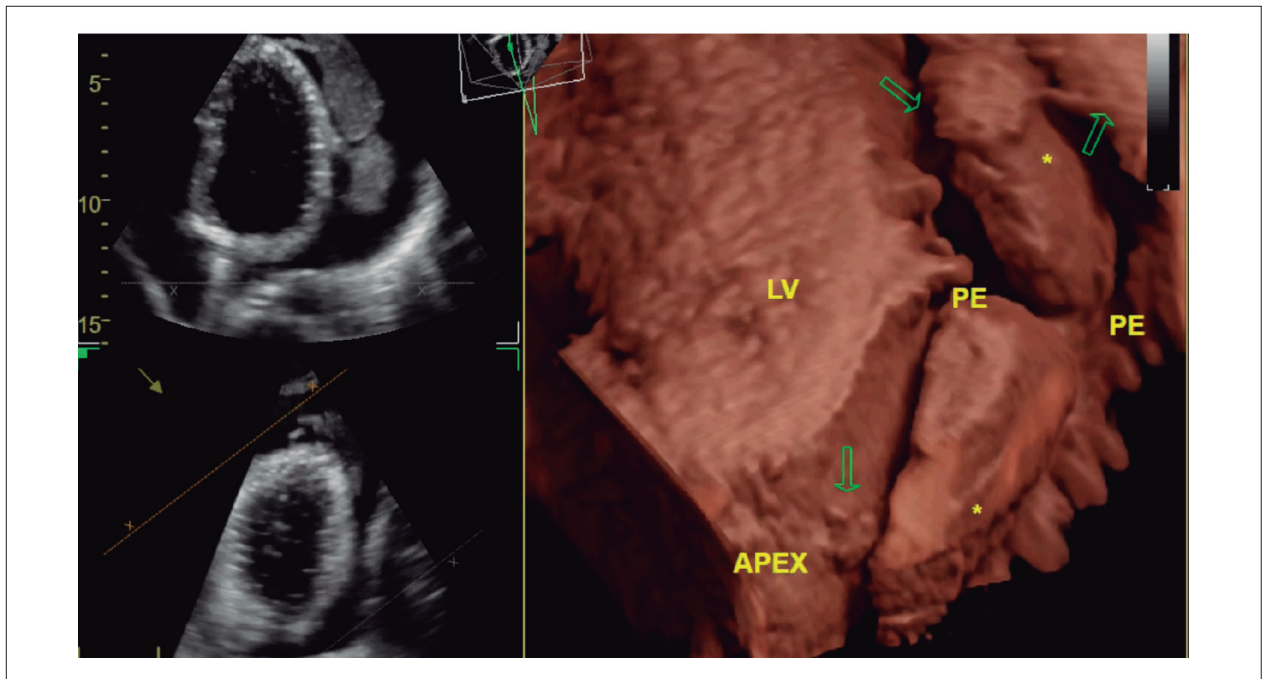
Transthoracic echocardiogram (TTE), showing large pericardial effusion with two intrapericardial masses (*). Two discoid masses were detected by 2D TTE, measuring 5.5 x 2.0cm and 4.3 x 2.3cm in its major diameters, from apical (A) and parasternal views (B). Rendered 3D images were obtained by post processing of datasets obtained by 3DTTE. Oblique 3D views in C, D and E show morphologic details of the masses, which are attached to visceral and parietal pericardial layers by fibrous strands (arrows), floating inside the pericardial fluid, without invasion of surrounding tissues. LV: Left ventricle; RV: Right ventricle; LA: Left atrium; RA: Right atrium; PE: Pericardial effusion.
